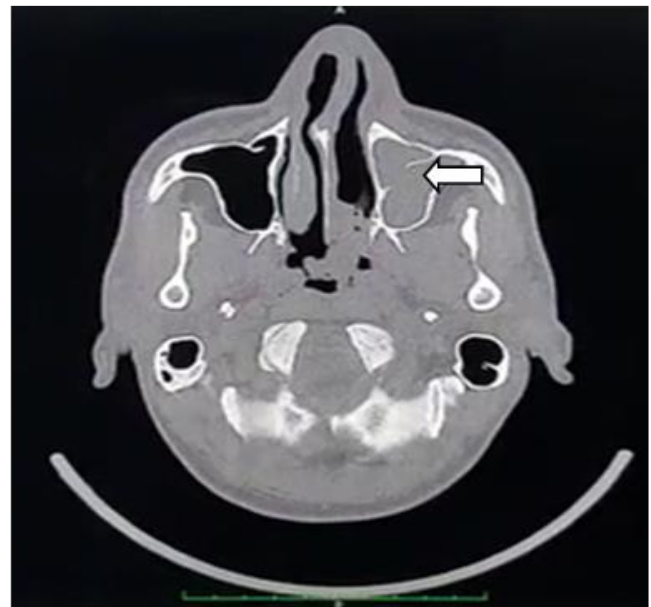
CT Paranasal sinus image showing isodense soft tissue density (arrow) extending into the nasal cavity on left side with adjacent bony thinning.
